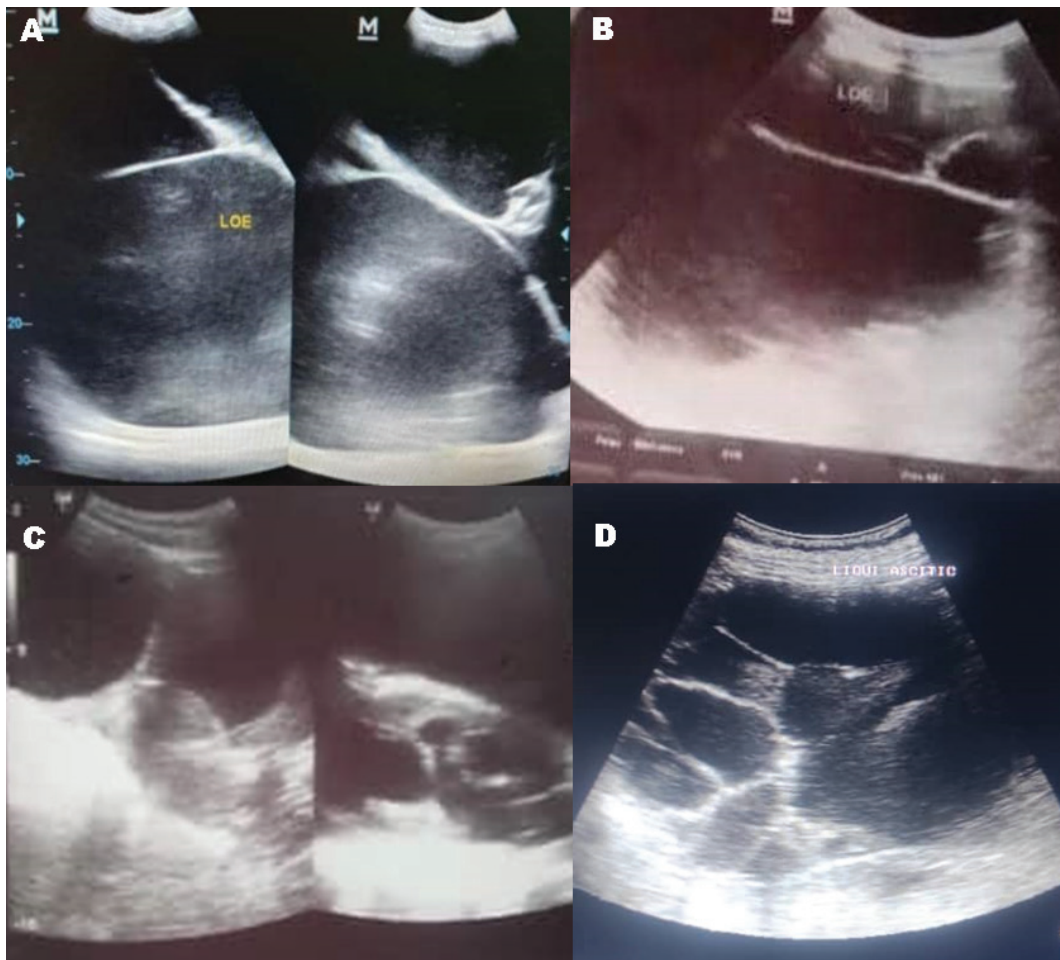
Ultrasound images of four cases of Giant Ovarian Tumor. A: Case 1, B: Case 2, C: Case 3, D: Case 4.
